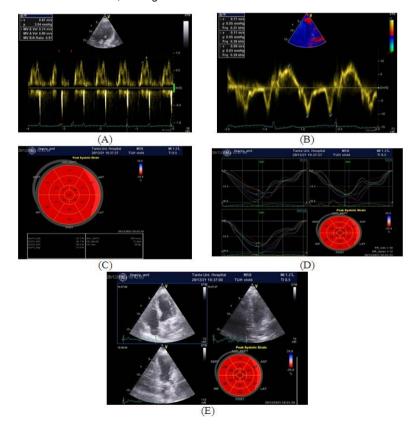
(A) Conventional echocardiography (B) Tissue doppler (C), (D), (E) Speckle tracking echocardiography assessment of LV systolic function, Bull's eye view of global longitudinal strain (LS), as mean of four, two and three chamber views 6.7, LAVI 30 ml/m²)
